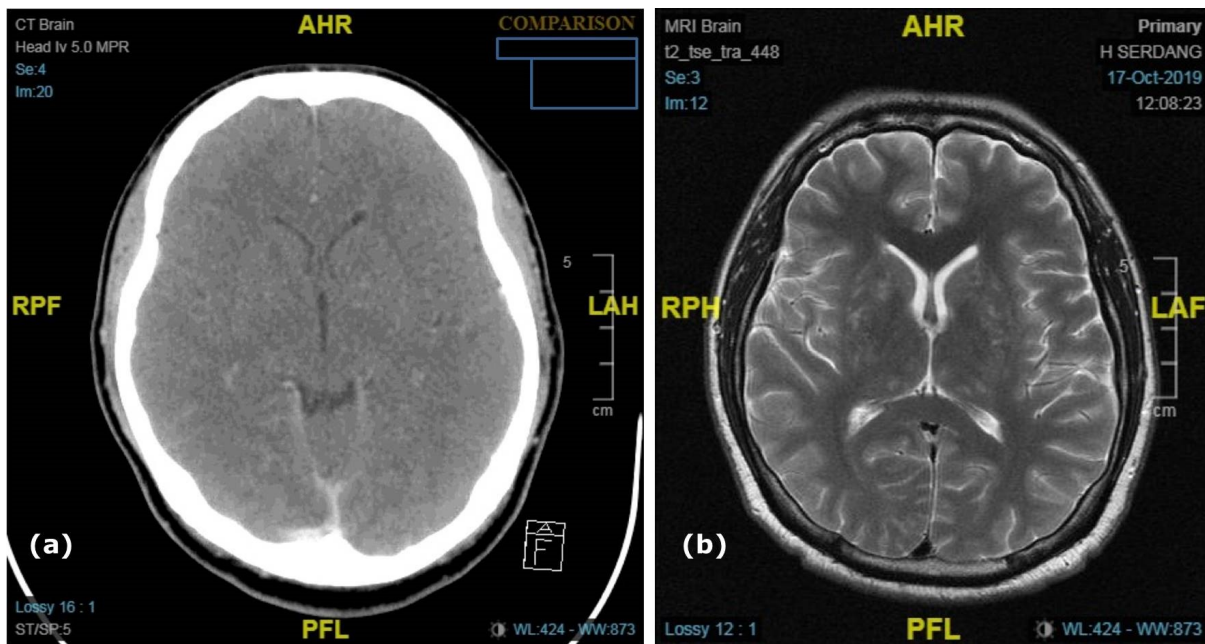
(a) CT angiogram of the brain showing focal leptomenigeal enhancement at the right high parietal region, with generalized mild cerebral oedema, (b) MRI Brain showing hyperintensities on bilateral basal ganglia and thalamus. (Click to enlarge image)
